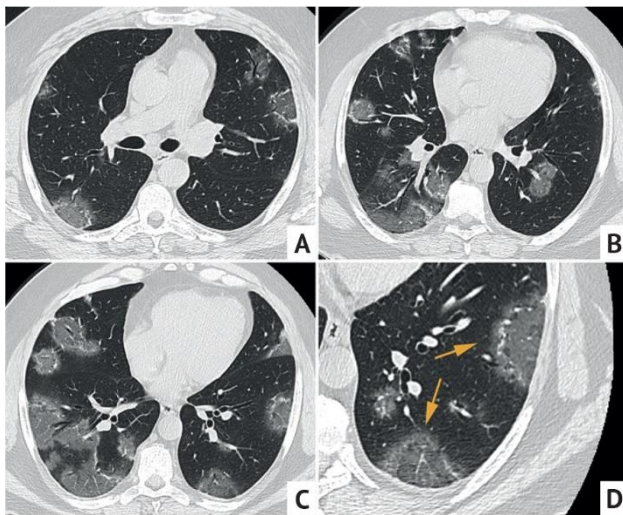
Axial chest CT images of 41 y.o patient (A–C) with enlarged fragment of left lung (D). COVID-associated lung damage. Opacities like “reverse halo” sign (arrows) without cavitating in both lungs. The type of current opacities differs from those in lung infarction — there is no typical reticulation on the background of GGO, a less pronounced rim of consolidation
